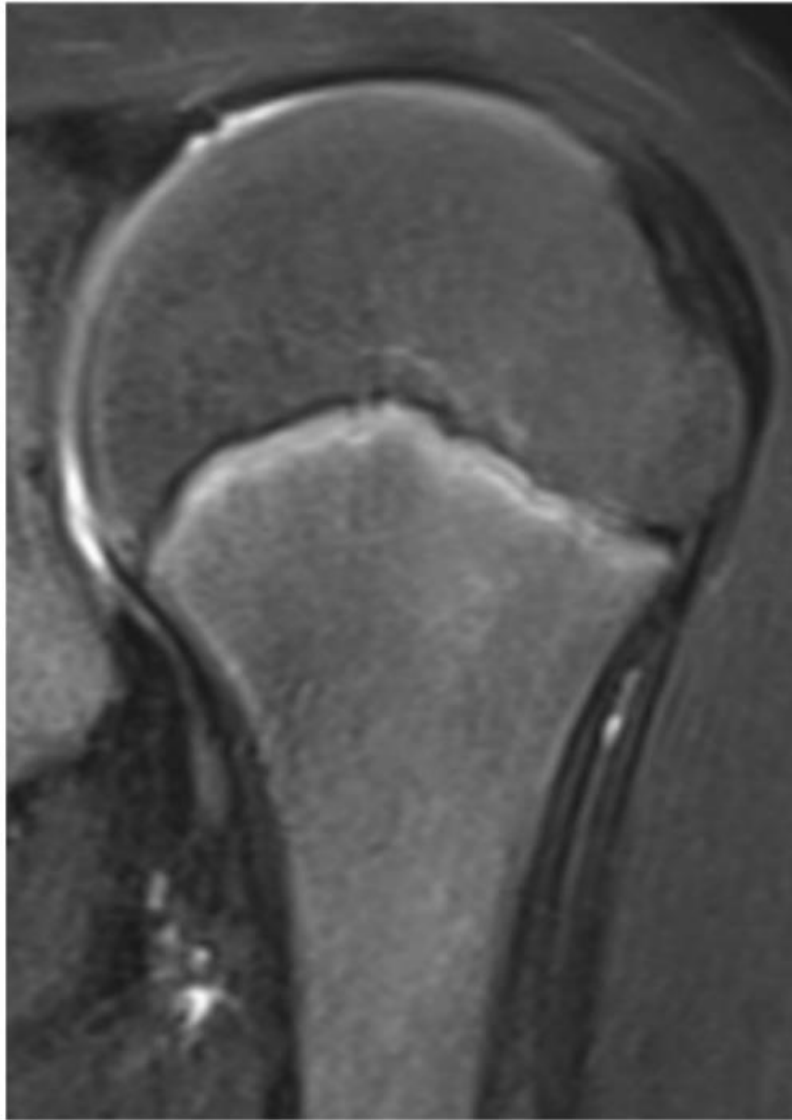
Fast-spin-echo proton density–weighted (FSE PD) sequences in coronal oblique orientation on shoulder MRI images: Stage 1 for proximal humeral epiphysis
